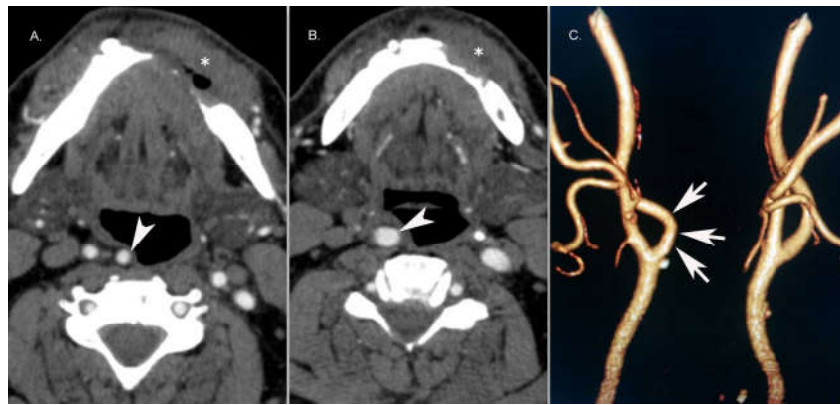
71year old male with retropharyngeal right CCA and ICA. A. & B. Axial CECT images in arterial phase showing retropharyngeal location of right CCA and ICA (arrowheads) and an ill-defined mass (asterisk) is seen involving left gingivobuccal sulcus with destruction of underlying mandible C. Coronal volume rendered CT image showing abrupt medial deviation of the right ICA
